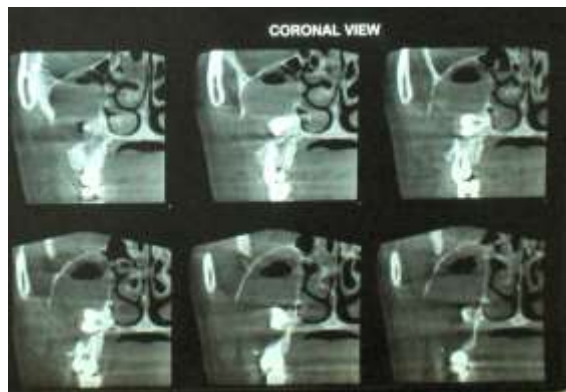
Coronal view CBCT
